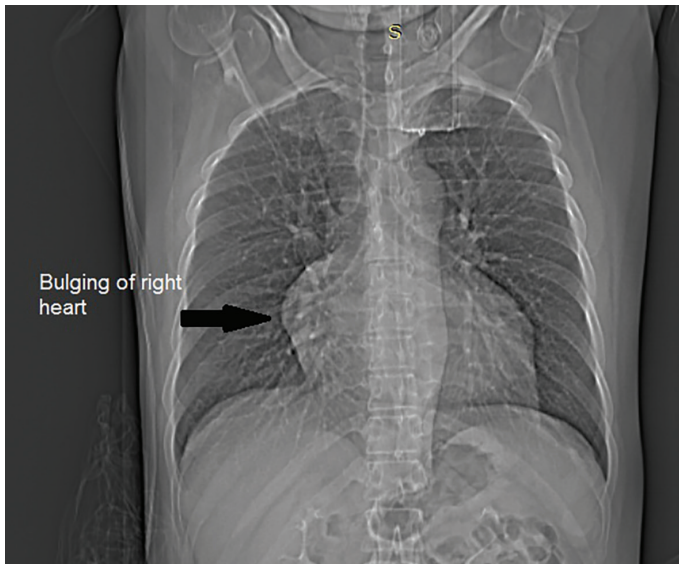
Chest radiography revealed a bulge on the right side of the heart.
